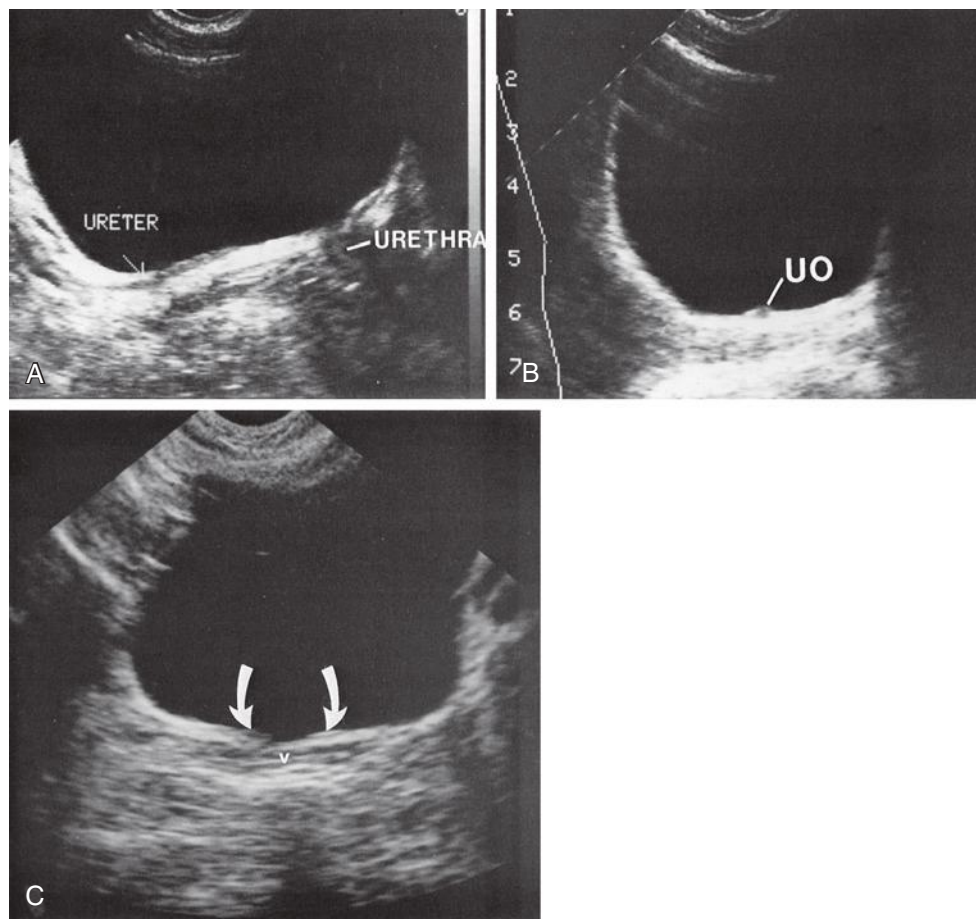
A, Longitudinal transabdominal sonogram of the right ureter and urethra. B, Longitudinal transabdominal sonogram of the right ureteric orifice (UO). C, Transverse transabdominal sonogram of both ureteric orifices (*curved arrows*). v, vagina.
